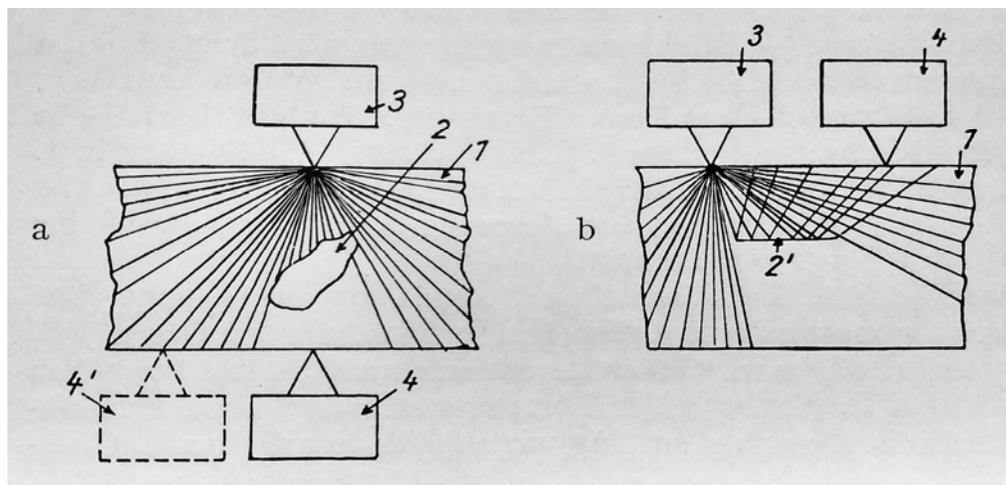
Ultrasonic materials testing by transmission (a) and reflection (b). 3: transmitter: 4,4': receiver. Mühlhäuser 1931. [94]
